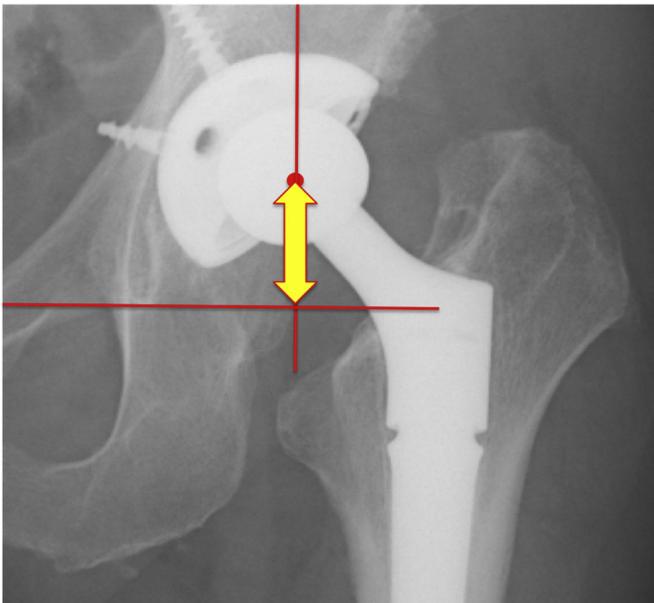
Vertical distance from hip center to interteardrop line. The horizontal red line in this radiograph is the interteardrop line; a vertical line has been drawn perpendicular to the interteardrop line. The vertical distance between the interteardrop line and the hip center is denoted by the yellow arrow.
